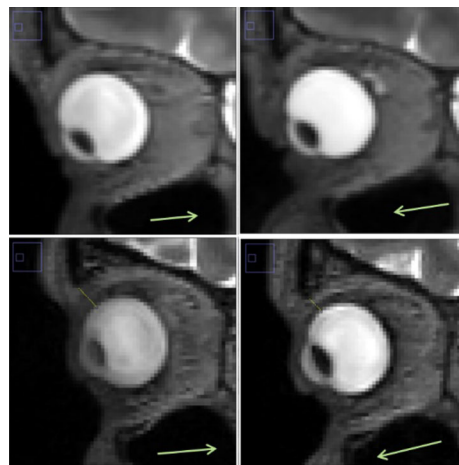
Example images of two participants (one in each row) showing eye position in supine (left) and prone (right) MRI images. Top row shows zero shift, bottom row shows 2 mm shift and arrows show direction of gravity
